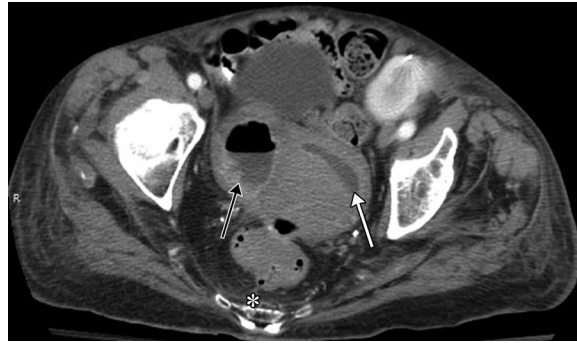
Ruptured pyometra in an 82-year-old woman with abdominal pain and a history of actinomycosis, who now presented with a purulent vaginal discharge. Axial contrast-enhanced CT image shows an abnormally dilated and fluid-filled endometrial cavity (white arrow) with an adjacent peripherally enhancing abscess (black arrow) containing an air-fluid level. Note the thinning of the uterine wall adjacent to the abscess, as well as the presacral fat stranding (*).
